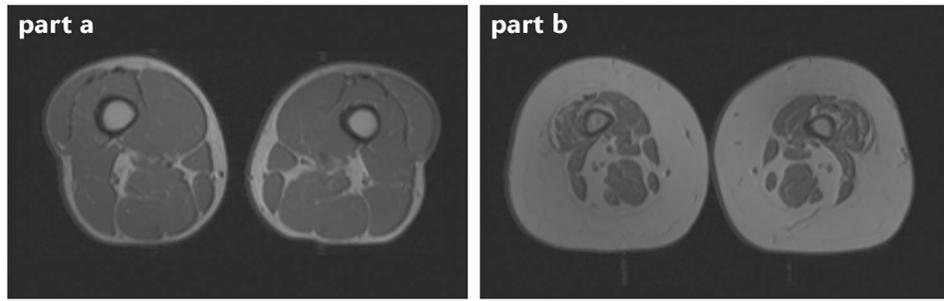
MRI of individuals with and without obesity.
